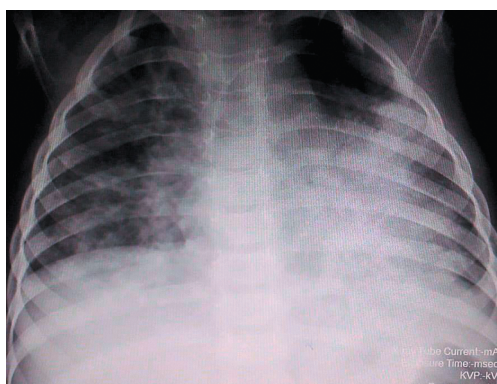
Chest radiography (12th day of hospitalization) (photo from the authors' personal archive)
